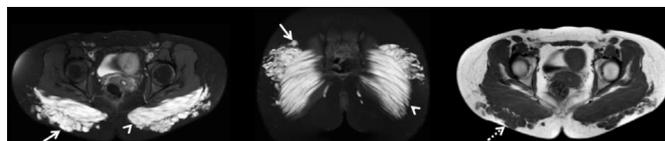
(a) Axial and (b) Coronal T2 with fat saturation; (c) Axial T1. 29-year-old patient. Local filling procedure with PAAG 2 months ago. Conglomerates of rounded images with a high signal at T2 weighting in the gluteal regions' subcutaneous region (arrows). Similar diffuse alteration of signal in the gluteus maximus is observed (arrowheads). The material has a muscle-like signal in T1-weighted images (dotted arrow).
